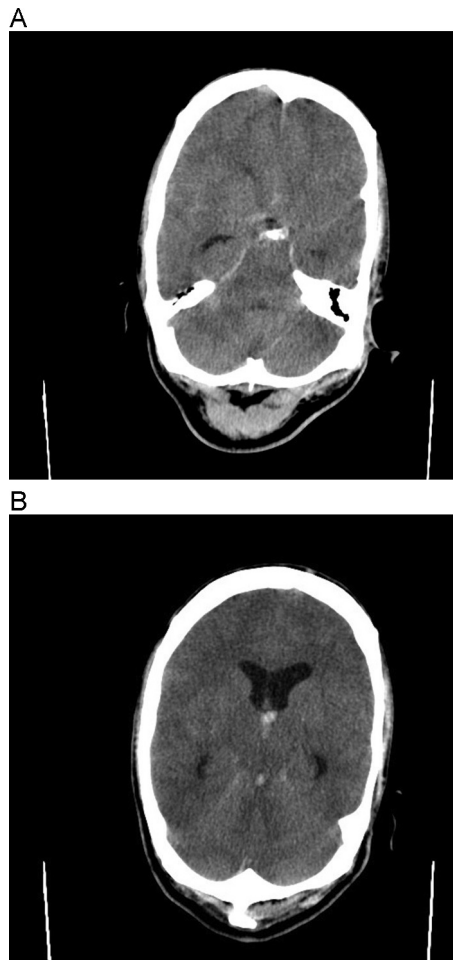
(A and B) CT scan showed diffuse subarachnoid hemorrhage in basal cisterns and intraventricular hemorrhage.
